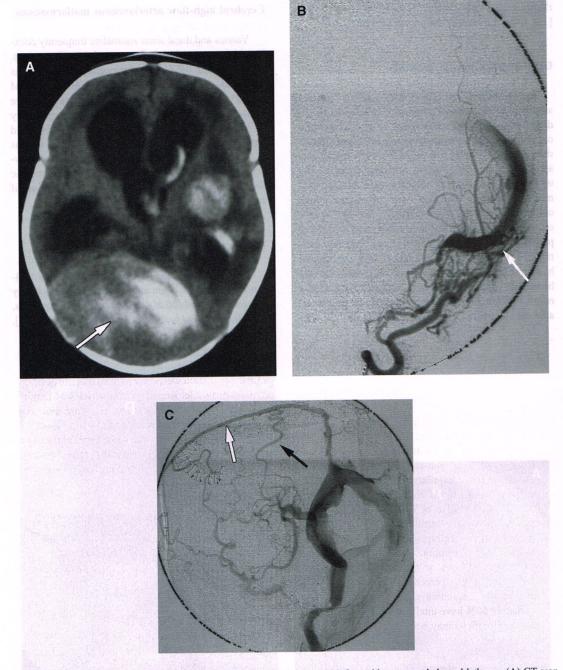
Dural AVM with thrombosed dural sinus anomaly, in a 6-week- old infant with macrocephaly and lethargy. (A) CT scan with contrast shows the large, partly thrombosed torcular venous pouch (*arrow*), hydrocephalus (secondary to cerebral venous hypertension), and hemorrhagic venous infarcts. (B,C) Occipital artery angiogram, lateral projection, arterial (B) and venous (C) phases, demonstrates the AVF into the partly occluded transverse sinus (*arrow*) (B), and retrograde opacification of the superior sagittal sinus (*open arrow*) (C) and cortical veins (*closed arrow*) (C).
